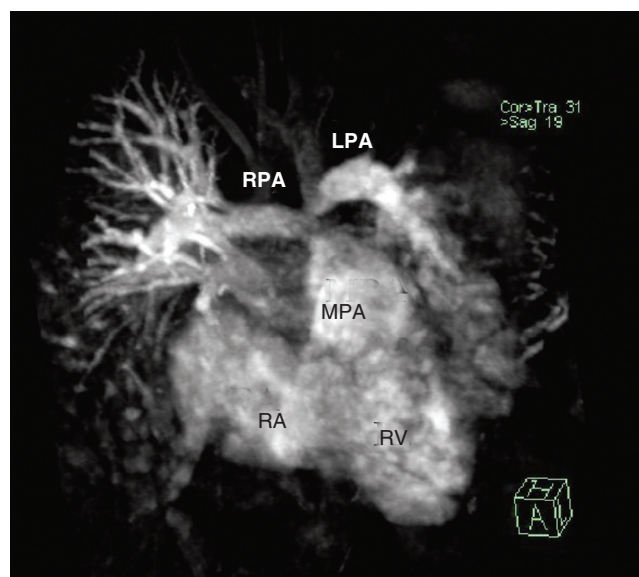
■ Magnetic resonance imaging at follow-up. Three-dimensional reconstruction shows the dilated right ventricle (RV) and main pulmonary artery (MPA). Note the proximal stenosis at the left pulmonary artery branch (LPA) origin. RA, Right atrium; RPA, right pulmonary artery. (Courtesy Dr. Martina Perazzolo Marra.)
